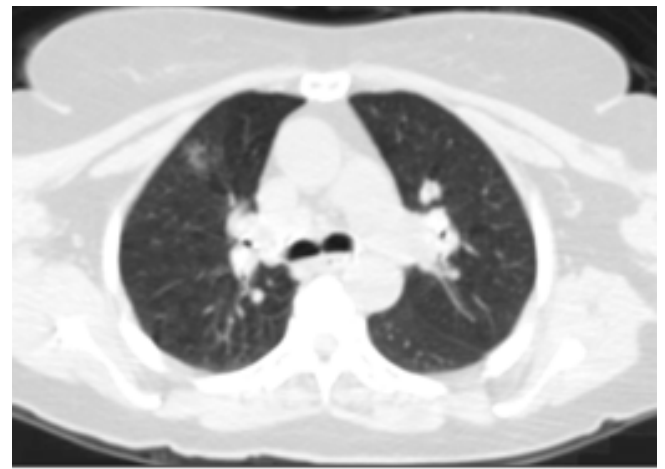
Parenchymal nodules, sequels and atelectasis of a sarcoidosis patient on CT parenchyma window imaging.
